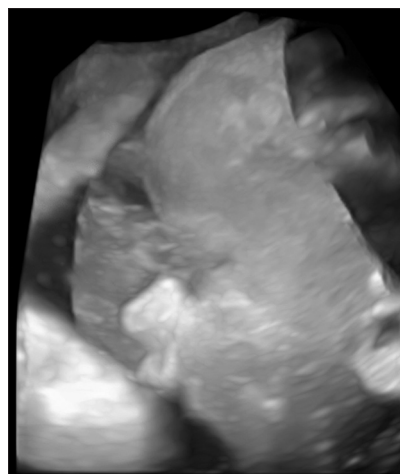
Third-trimester ultrasound: 3D reconstruction of the abnormal fetal profile highlighting the prominent upper lip and receding chin
